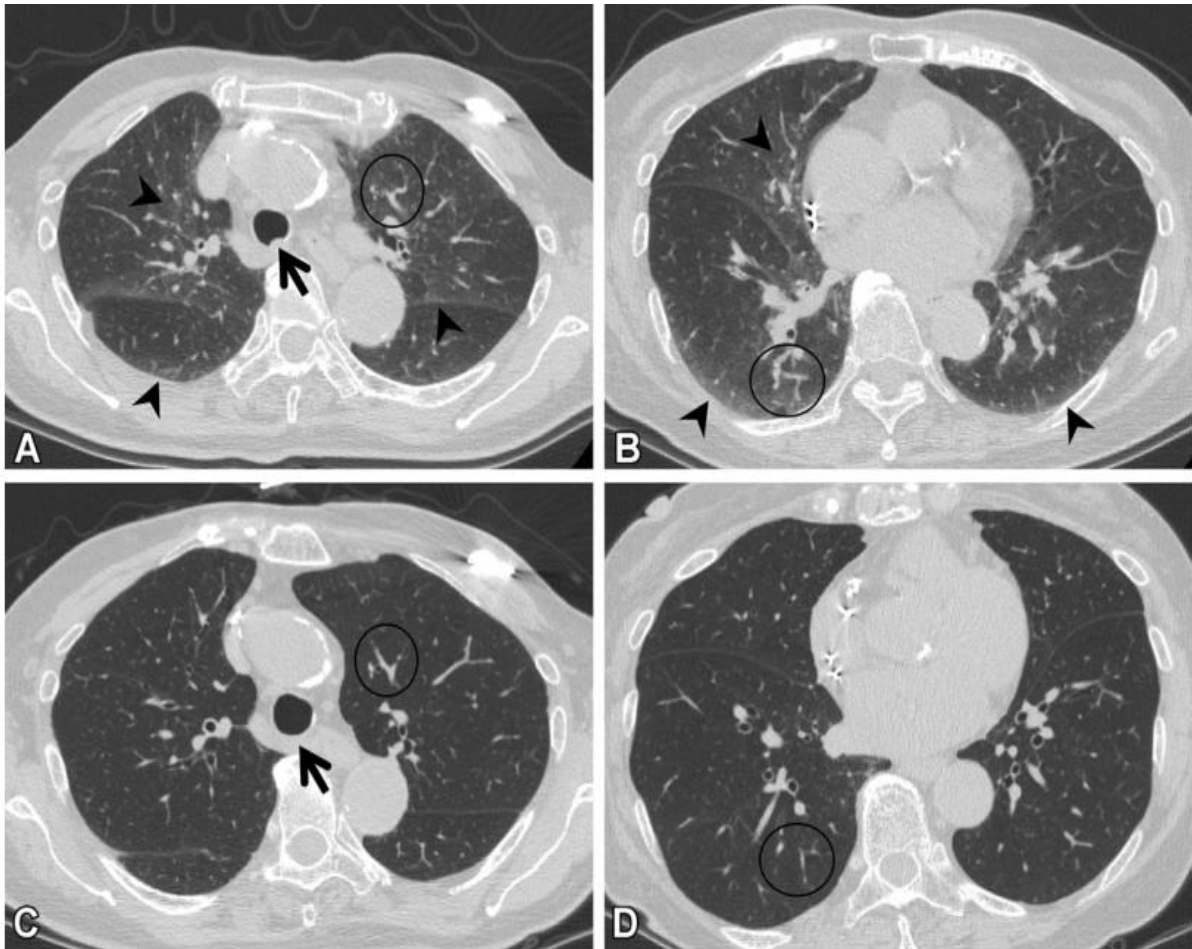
(A, B) CT images show ground-glass abnormalities (arrowheads) in subpleural and central areas of the lung zone. Anterior bulging of the posterior membranous portion of the trachea (arrow in A) and tortuosity of the vessels (circle) suggest a suboptimal inspiration; (C, D) Follow-up axial CT images show that the ground-glass abnormality has disappeared, and the normal round shape of the trachea is seen (arrow in C). The tortuosity of the vessels (circle) is no longer seen<sup>2</sup>
